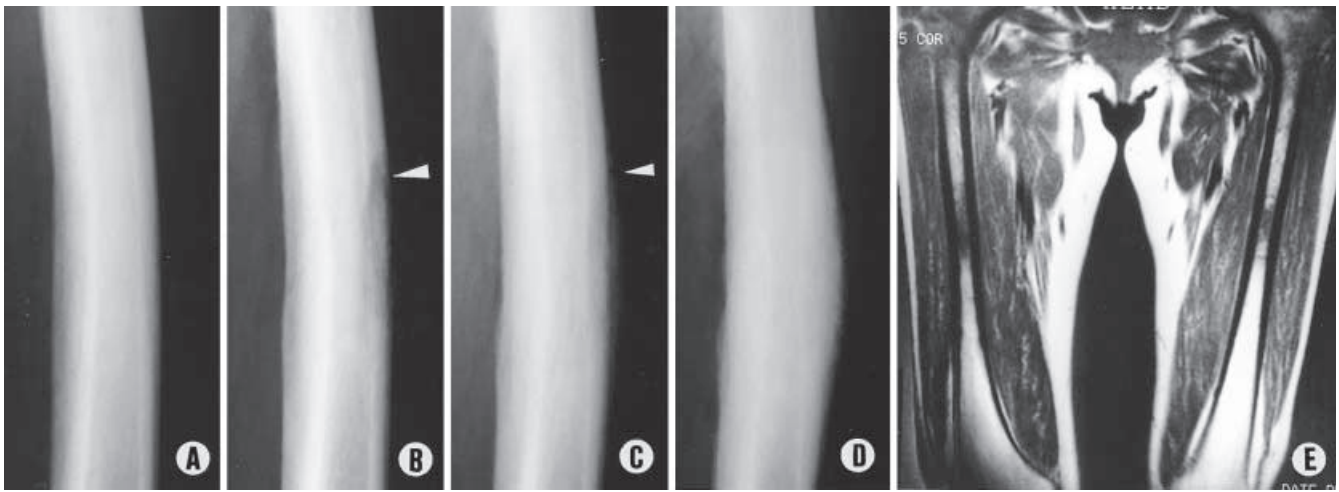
Case 3. Plain radiography of the left femoral shaft (nonbiopsy side) shows no marked change at consultation (A), radiolucency (arrowhead) of the cortex bone 3 weeks after onset (B), linear periosteal reaction (arrowhead) 12 weeks after onset (C), and cortical
